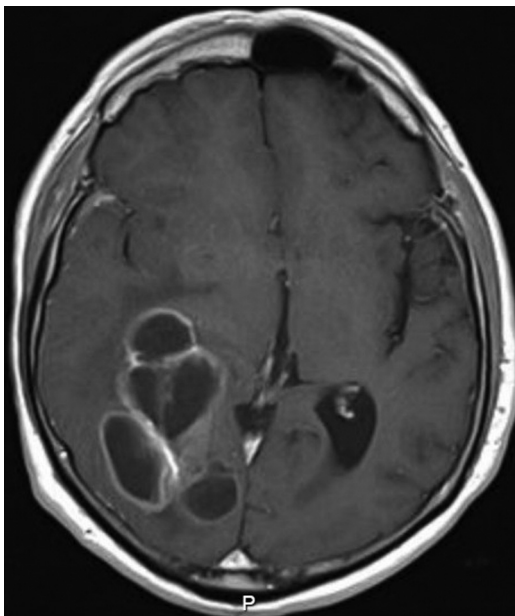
Gadolinium-enhanced T1-weighted magnetic resonance imaging (MRI) scan confirming the lesion.
